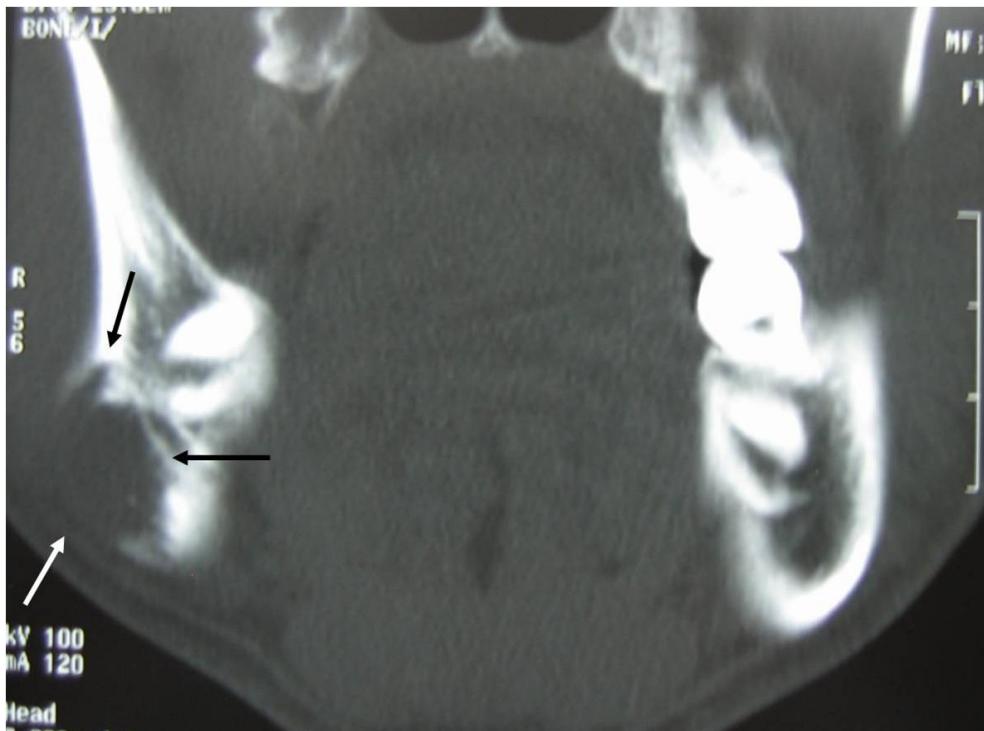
Coronal CT view of mandibular eosinophilic granuloma.
